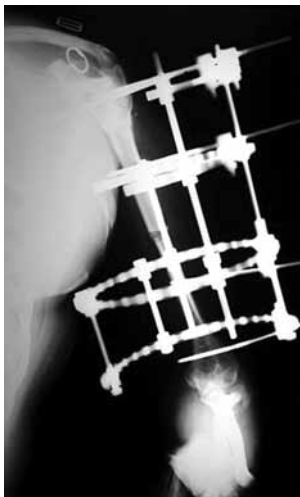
(a): Plain radiograph of left humerus of a 28 years old lady, 9-cm shortening as sequel of osteomyelitis, corticotomy of the middle part of the humerus
